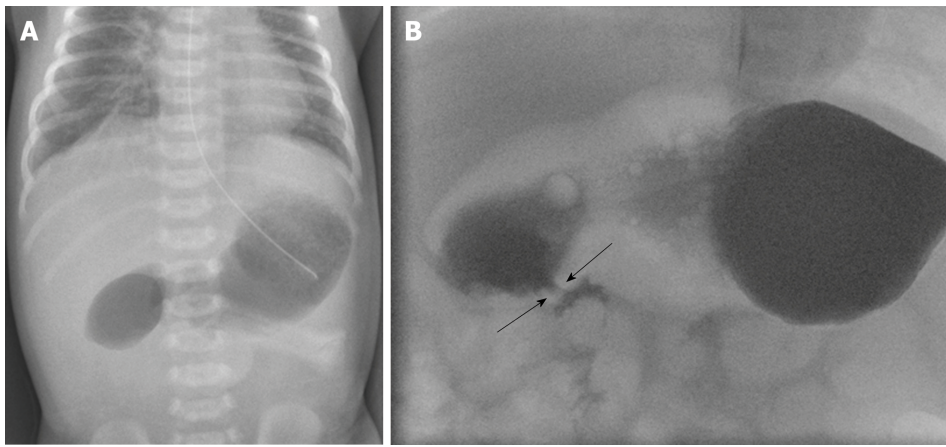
Radiographic images of complete and incomplete congenital duodenal obstruction. A: Complete congenital duodenal obstruction, the plain abdominal X-ray of a newborn infant with duodenal atresia type 1 displays a characteristic double bubble sign; B: Incomplete congenital duodenal obstruction, contrast study of a 2 month old infant with duodenal web (arrows).
